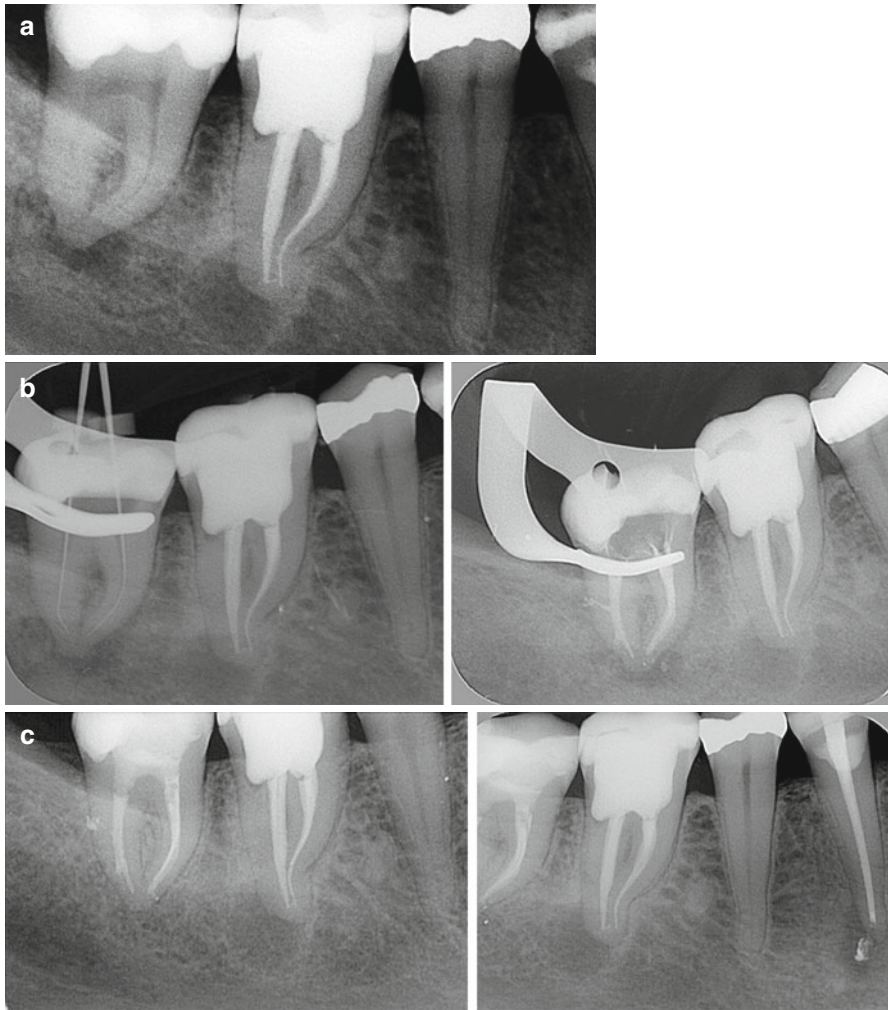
Radiographs showing details for the evaluation and treatment of the left mandibular second molar (tooth 46 FDI or #30 Universal). The patient is female, born 1945. There is pain from lower right jaw region; the tooth in question was root canal-treated 3 years earlier. Both right mandibular molars are tender to percussion, and the second molar is not sensitive to electric and thermal pulp testing. Radiographically, there are radiolucent areas associated with both molars. (a) Preoperative periapical radiograph. (b) *Left and right*, Root canal treatment of 47 (#31). Note the fill of lateral canal. (c) *Left and right*, Follow-up after 6 months. Asymptomatic patient. Note that 44 (#28) also has a root filling and a periapical radiolucent area. (d) *Left and right*, Additional follow-up 1 year later. Note bone fill apically to 47 (#31) and 44 (#28). However, periapical radiolucent area 46 (#30) persists. The tooth is slightly tender to percussion. The decision is made to perform surgical retreatment 46 (#30). (e) Immediate postoperative surgery 46 (#30). (f) *Left and right*, 1-year follow-up after surgery. Patient asymptomatic. Good healing of periapical lesions 47, 46, 44 (#31, 30, 28)
